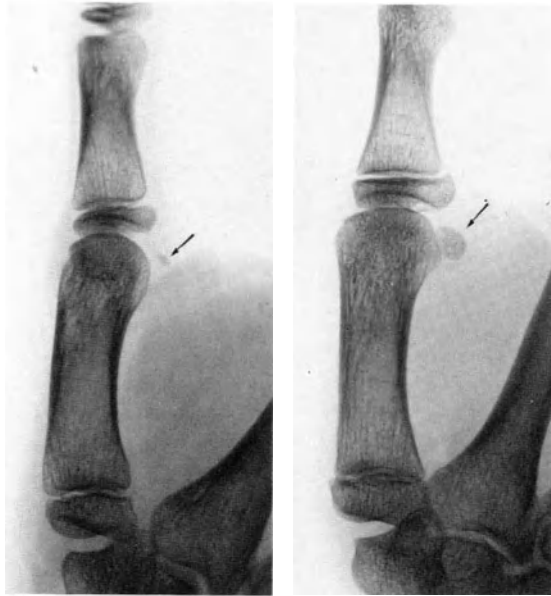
First sesamoid bone of the thumb shown on the X-ray. Left, in a boy at the age of 13; right, in a boy of 15 (KspZ)
